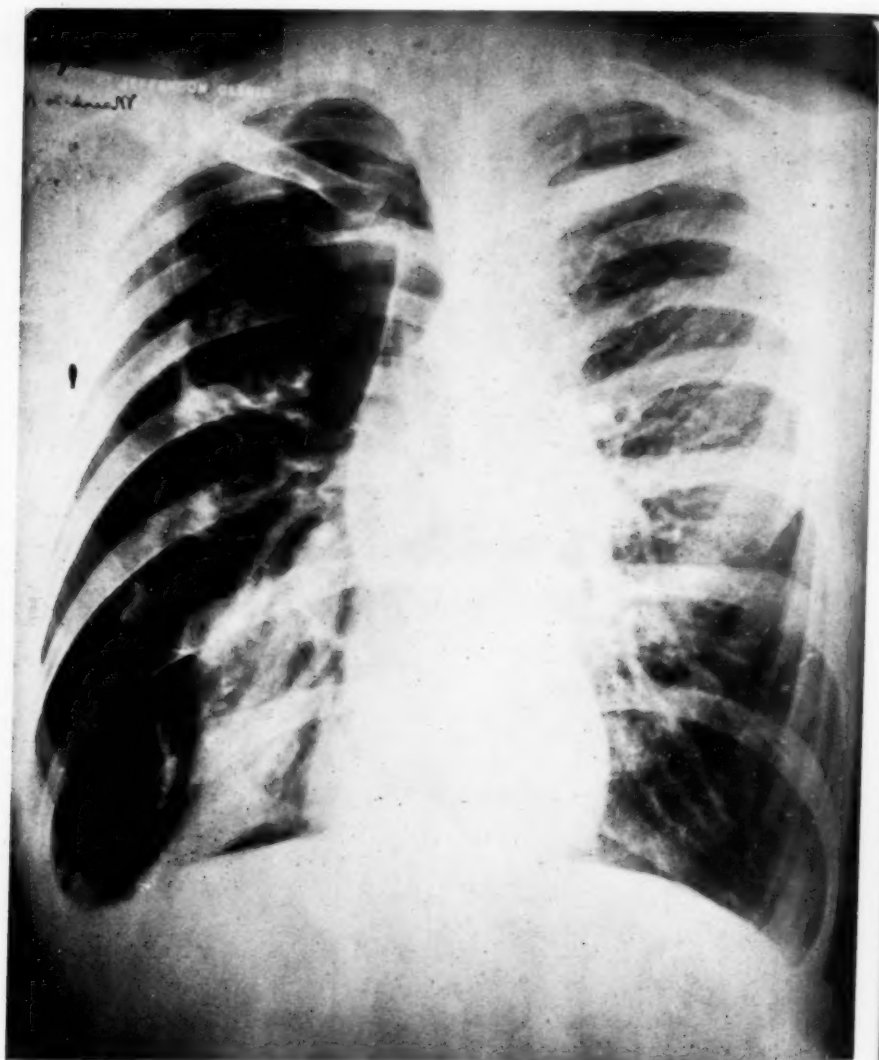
Radiograph of Case No. I four weeks after pneumothorax.
